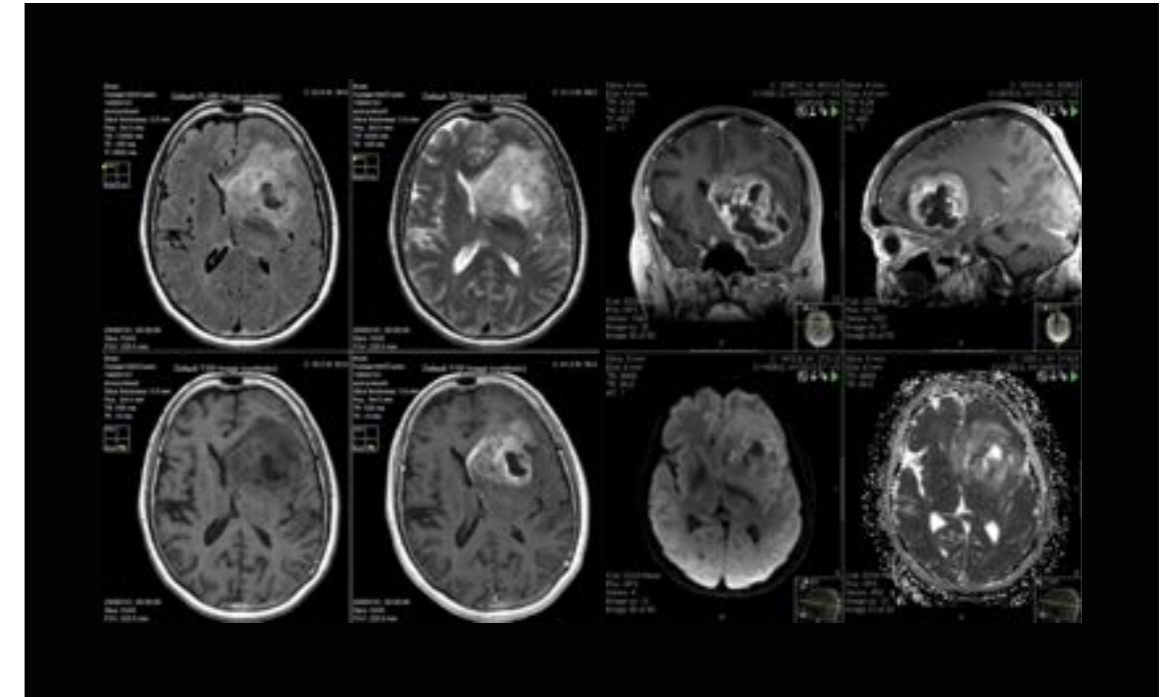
Set-up for the MR examination. On the left panel the axial SyMRI images: FLAIR (TR/TE/TI = 12000/100/2600 ms), T2W (TR/TE = 4500/100 ms), T1W (TR/TE = 500/10 ms) and T1W post-GD (TR/TE = 500/10 ms). On the right panel the conventional images; a coronal and sagittal reformat of a T1W BRAVO, diffusion-weighted (b=1000) and ADC map.
